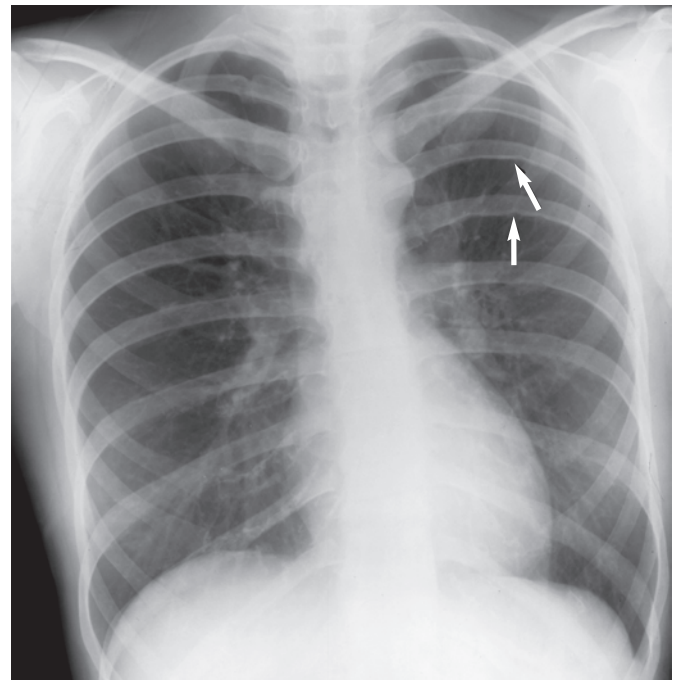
Chest radiograph of a patient with coarctation of the aorta showing notching (arrows) of ribs from collateral vessels.
